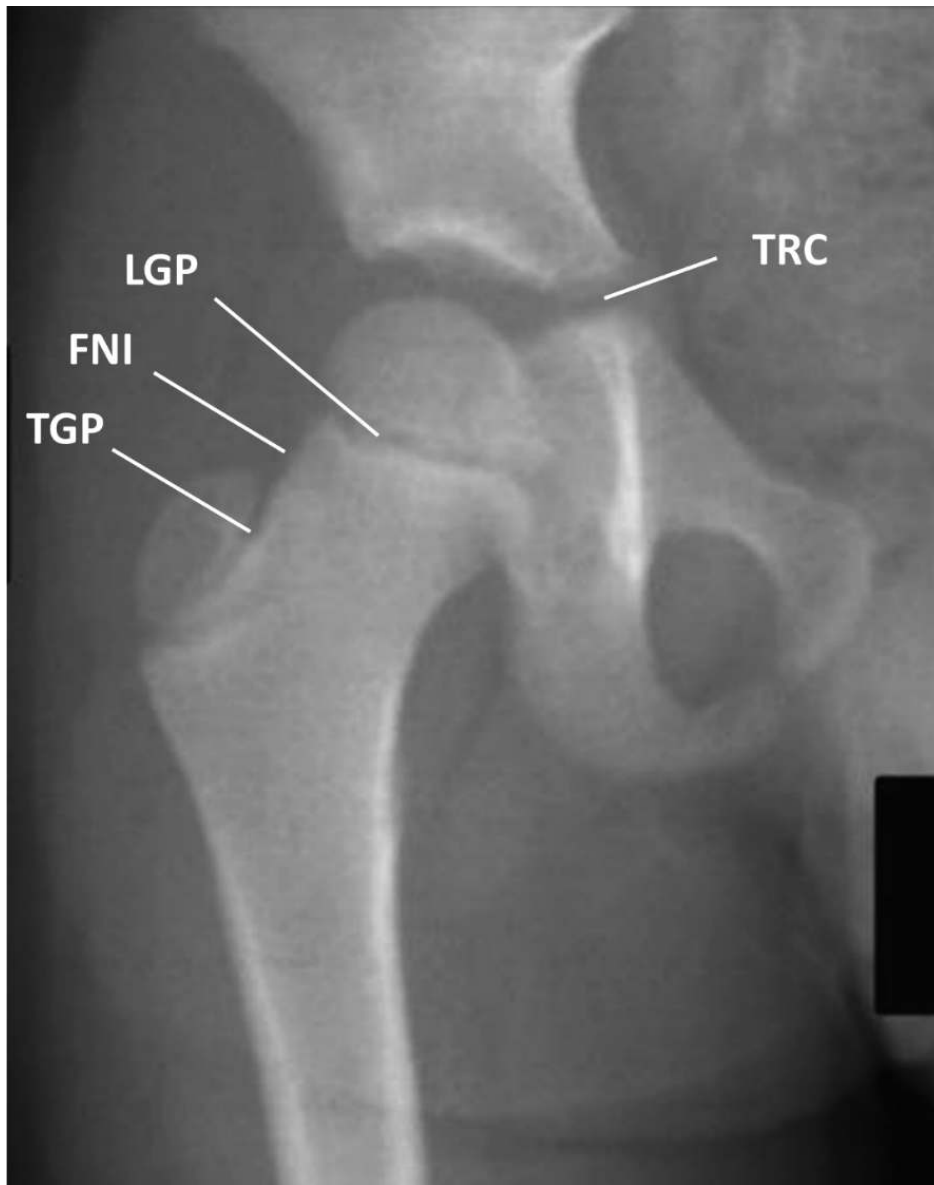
Growth plates of the proximal femur and the acetabulum on a dual-energy x-ray absorptiometry (DXA) image of the right hip in a 6-year-old child. TRC: triradiate cartilage; LGP: longitudinal growth plate; FNI: femoral neck isthmus; TGP: trochanteric growth plate.
